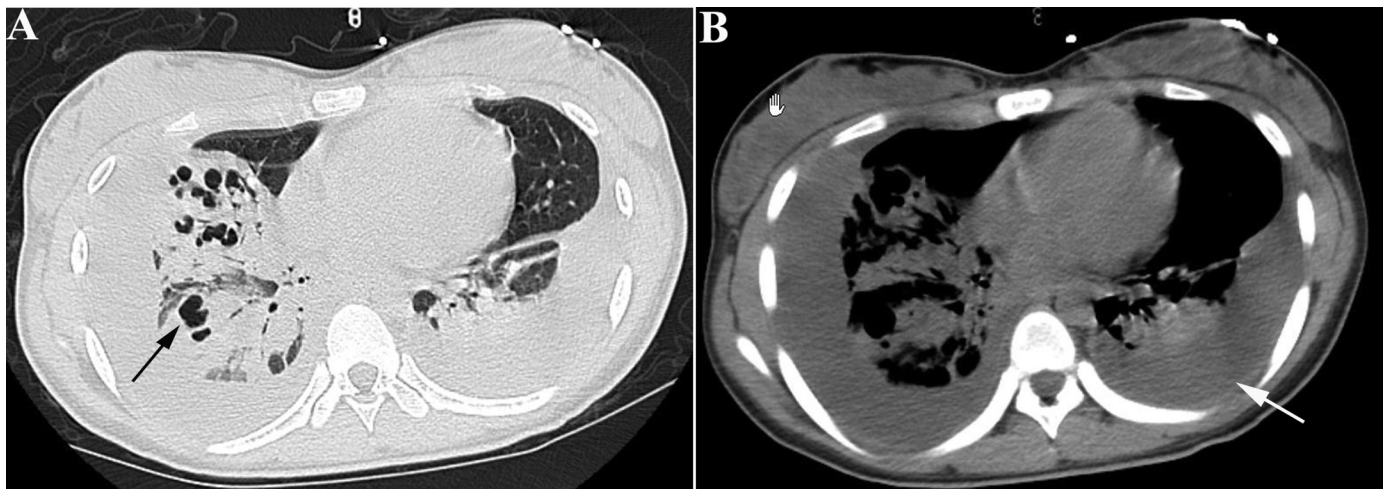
CT images at 8 days after the onset of pneumonia, showing multiple cavitary lesions in both lungs (A, black arrow) and bilateral pleural effusion (B, white arrow).
